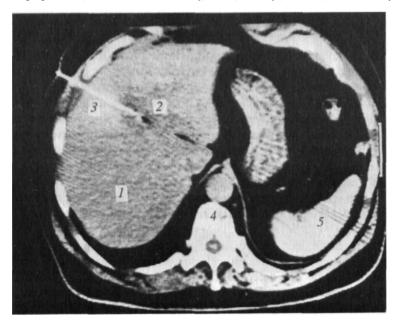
CT scan of puncture of liver abscess. 1—liver; 2—liver abscess; 3—puncture needle; 4—vertebra; 5—spleen.
